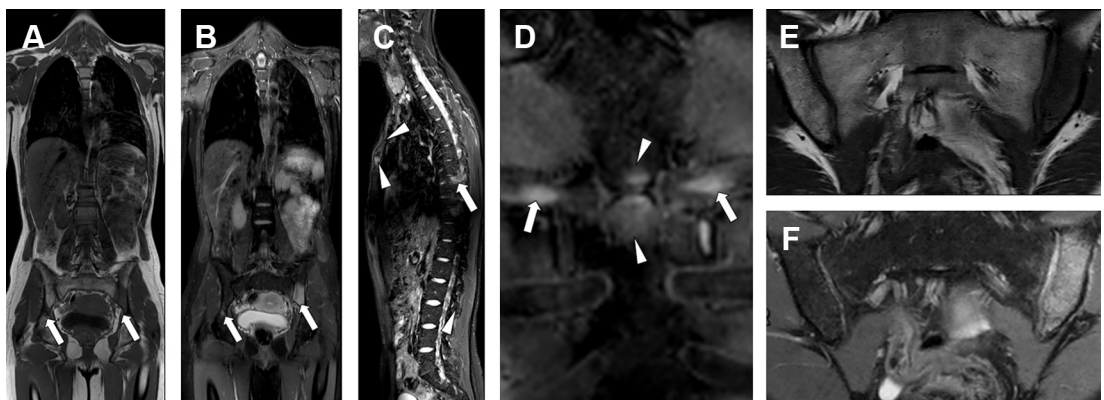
WB MR imaging from a 38-year-old female patient with SAPHO syndrome (multifocal aseptic osteitis associated with palmoplantar pustulosis). Coronal T1 (A) and STIR (B) MR imaging of the WB and sagittal STIR images (C) of the spine show concurrent bone lesions at the level of the right and left iliac bone, and 1 thoracic vertebra (arrows in A–C) and suggest manubriosternal involvement (arrowheads in C). Zoomed coronal STIR image of the manubriosternal joint (D) confirms the involvement of this joint (arrowheads in D) and the adjacent second ribs (arrows in D). Oblique coronal T1 and STIR images (E, F) of the sacroiliac joints confirm an extensive lesion within the left iliac bone (arrows in E and F). The coexistence of bony lesions and anterior chest wall involvement, along with a clinical history of skin lesions, is pathognomonic of the disease.
